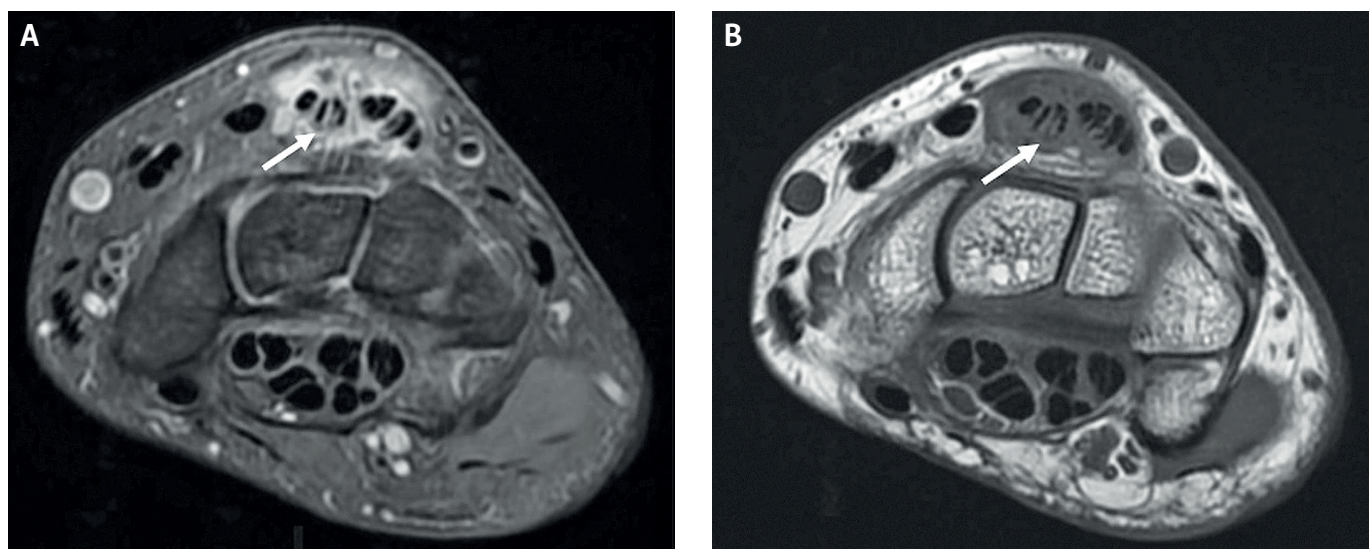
Right wrist MRI DP FAT SAT sequence (A) and T1 sequence (B) in axial section detecting fluid effusion in the sheath of the common extensor tendons of the fingers, and a thickened anomalous extensor indicis proprius (EIP) tendon with intermediate signal and surrounding fluid effusion, characterizing peritendinitis of the fourth extensor compartment due to a degenerated anomalous EIP tendon (white arrows). The set of findings is compatible with extensor index finger syndrome.
